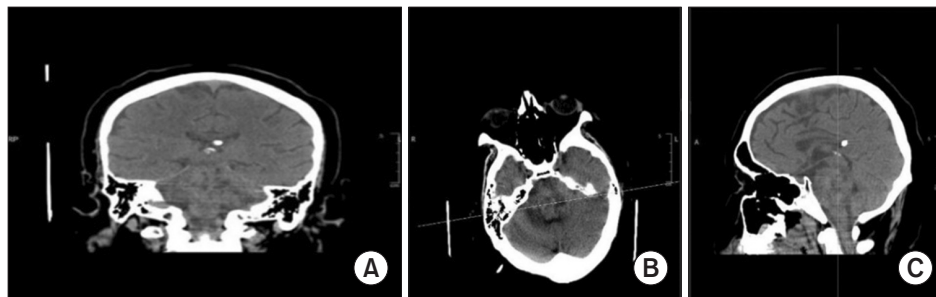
CT scan obtained in a 23-year-old man with pontine mass. (A) Coronal view. (B) Axial view. (C) Sagittal view.
